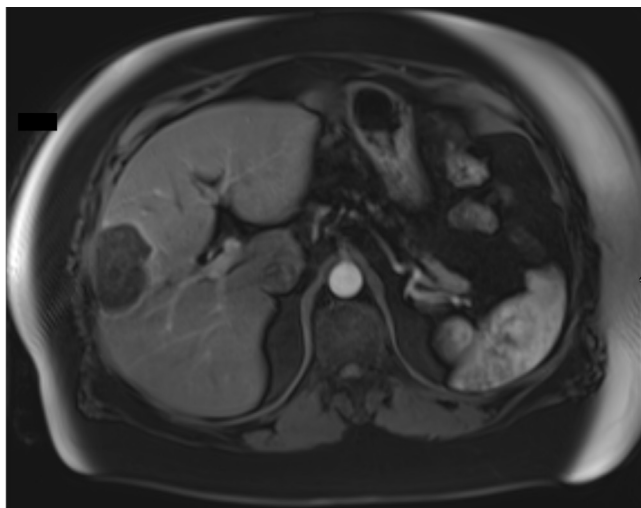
Follow-up MRI of abdomen after 3 months showed post-radioembolization changes in the right hepatic lobe without residual or recurrent tumor, compatible with treated non-viable lesion.
